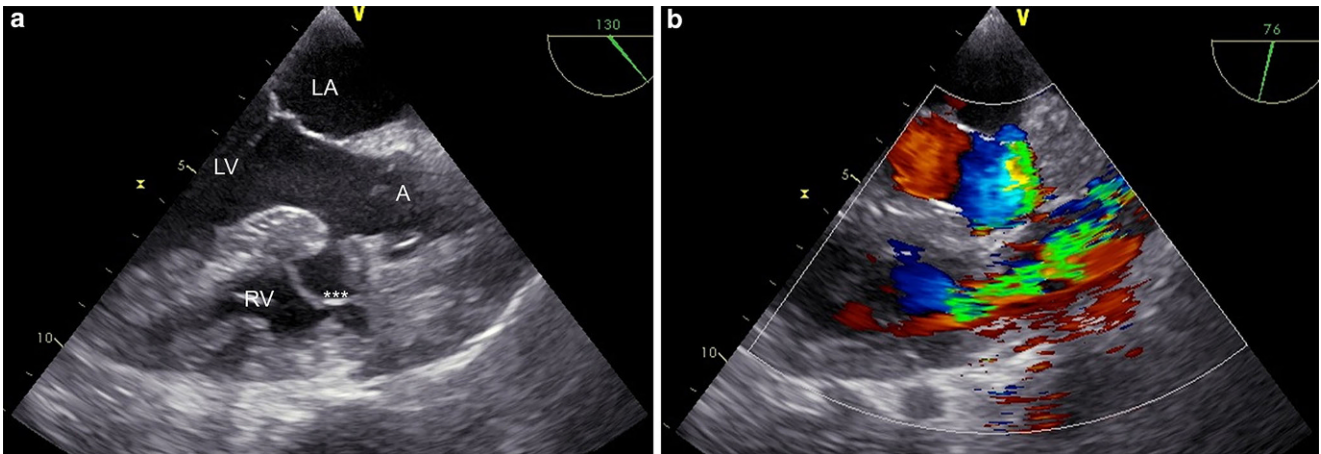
Transoesophageal echocardiography. a Membranous septum aneurysm dynamically obstructing RVOT during systole. See also online videos; b RVOT Doppler tracings showing signs of stenosis (maximal gradient 92 mmHg, mean gradient 38 mmHg). (LA left atrium, LV left ventricle, A aorta, RV right ventricle. *Interventricular membranous septal aneurysm)
